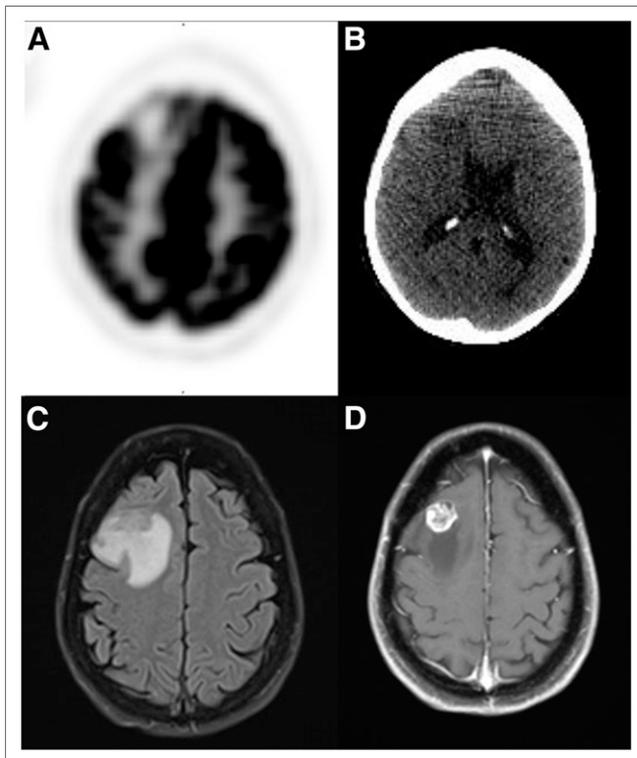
Axial ¹⁸F-FDG PET image of brain demonstrates focal hypometabolism in the right frontal lobe (A) corresponding to vasogenic edema on low-dose CT images (B). Subsequent axial T2-FLAIR and contrast-enhanced MR images confirm metastasis with adjacent vasogenic edema (C and D).
